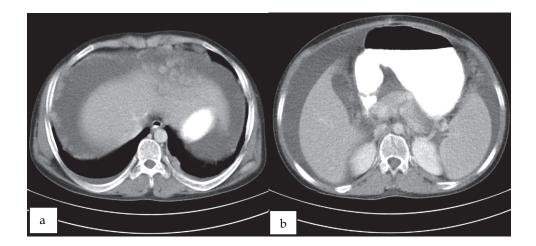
Malignant peritoneal mesothelioma. a. Contrast enhanced CT scan shows nodular peritoneal thickening. b. Axial contrast enhanced CT shows perisplenic and perihepatic large amount of ascites. c. Axial contrast enhanced CT shows diffuse peritoneal thickening with omental cake.
